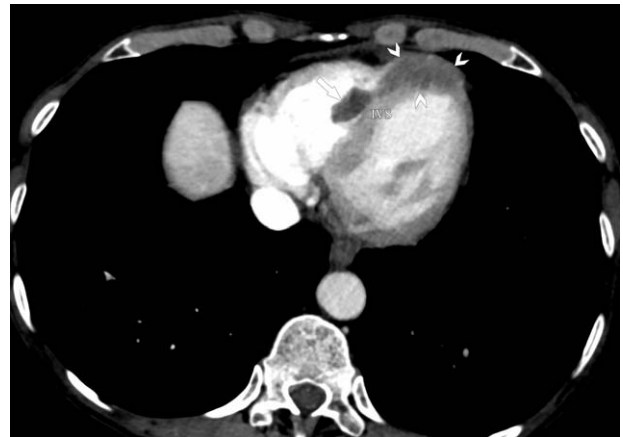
Axial contrast-enhanced CT (delayed phase) at the same level as Fig. 2 shows the low-attenuating myocardial mass (arrowheads), in contact with the intraventricular thrombus (arrow), infiltrating the apical myocardium and the interventricular septum (IVS), consistent with a cardiac metastasis. CT = computed tomography.
